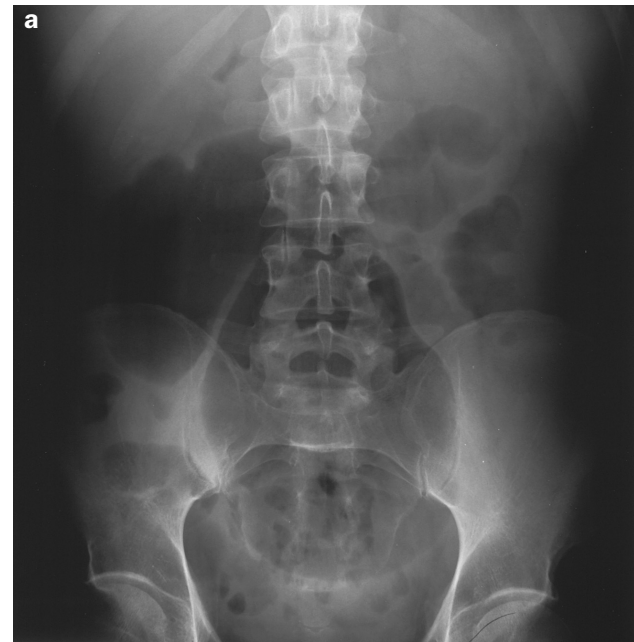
Abdominal radiographs of a patient with acute colonic pseudo-obstruction. (a) The plain abdominal film shows marked dilatation, especially of the right colon. In addition, moderate small bowel dilatation is present. (b) A water soluble contrast enema was obtained excluding mechanical obstruction
